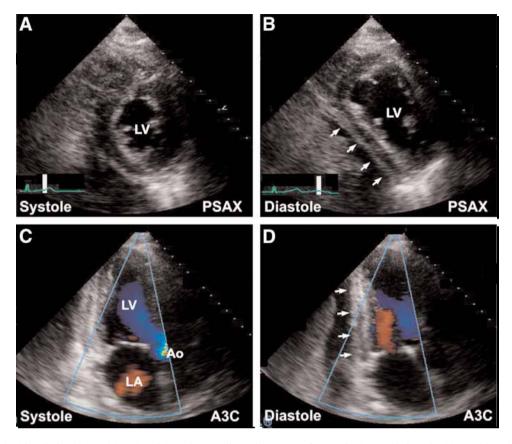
Case presentation: 80-yr-old male with hypertension and acute-onset chest pain. Parasternal long-axis (PLAX) and short-axis (PSAX) images from an 80-yr-old male with acute-onset chest pains. Note marked antero-septal hypokinesis (arrows) of left
